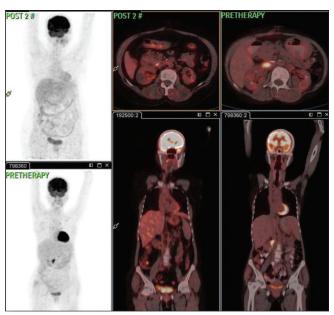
Comparison of fluorodeoxyglucose positron emission tomography-computed tomography in case 2
